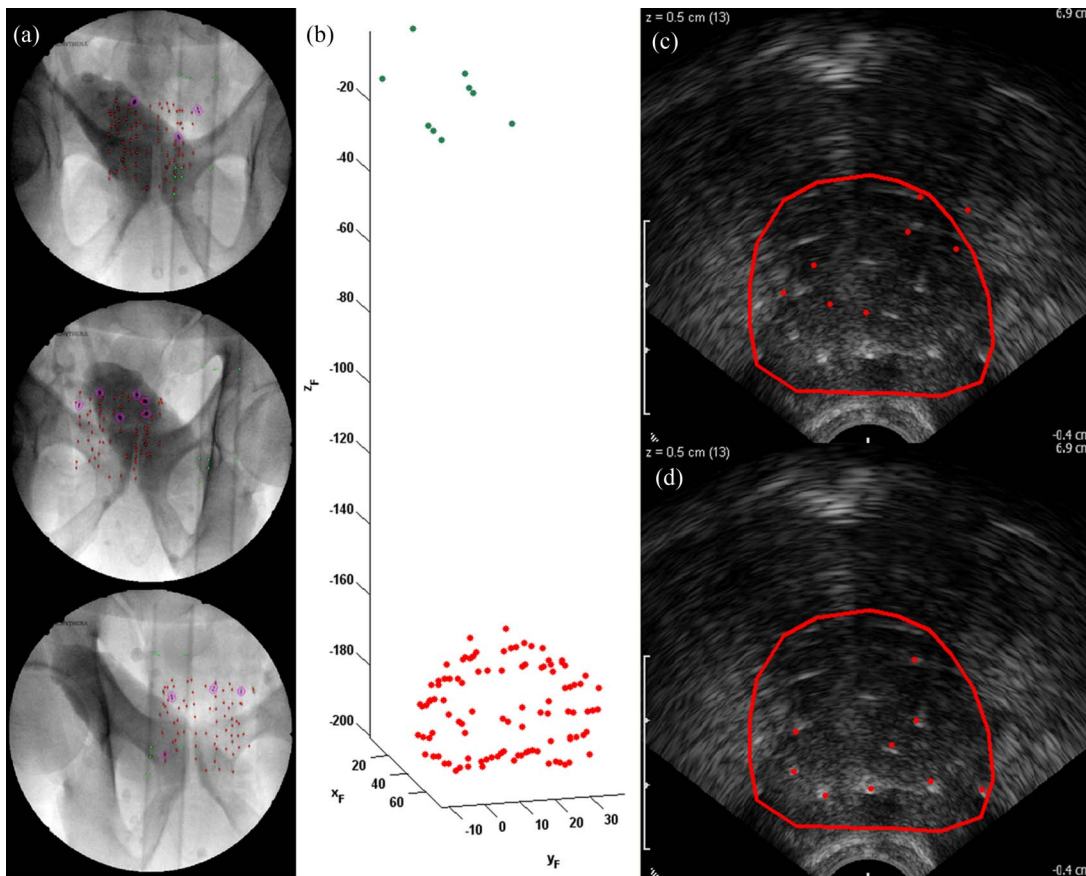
Seed reconstruction from fluoroscopy and registration to TRUS. (a) Three fluoroscopic images with segmented seeds and fiducial. At least three fluoroscopic images are needed for the reconstruction. (b) Reconstructed seeds (dots below) and fiducial (dots above). Note that the fiducial is properly separated from implanted seed cloud. (c) Before registration. The reconstructed seed cloud (dots) is centered on the ultrasound volume with the prostate contour. (d) After registration. Note that the registered seeds are positioned on the hyperechoic regions.
